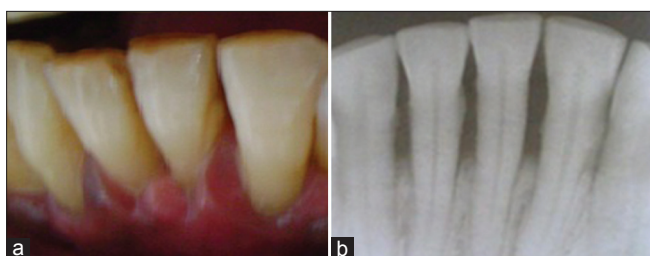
(a) Clinical photograph of case 3 (b) Intraoral Periapical Radiograph of case 3
